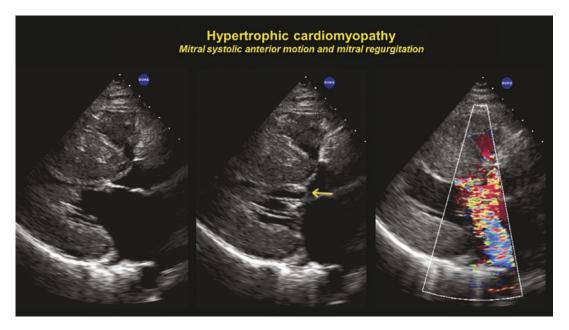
Two-dimensional echocardiograms from a patient with hypertrophic cardiomyopathy. The left panel shows a diastolic parasternal long axis view with the mitral leaflets open. The middle panel show a systolic
